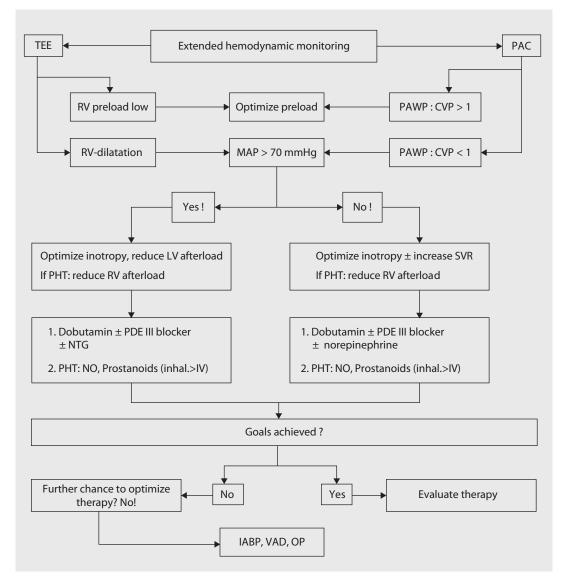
Therapeutic algorithm for right heart failure according to data from extended monitoring. *IABP* intra-aortic balloon pump, *OP* redo surgery, *PAC* pulmonary artery catheter, *PAWP* pulmonary artery wedge pressure, *PDE III* phosphodiesterase III, *TEE* transesophageal echocardiography, *VAD* ventricular assist device. *CVP* central venous pressure, *LV* left ventricular, *MAP* mean arterial pressure, *NO* nitric oxide, *NTG* nitroglycerin, *PHT* pulmonary hypertension, *RV* right ventricular, *SVR* systemic vascular resistance
